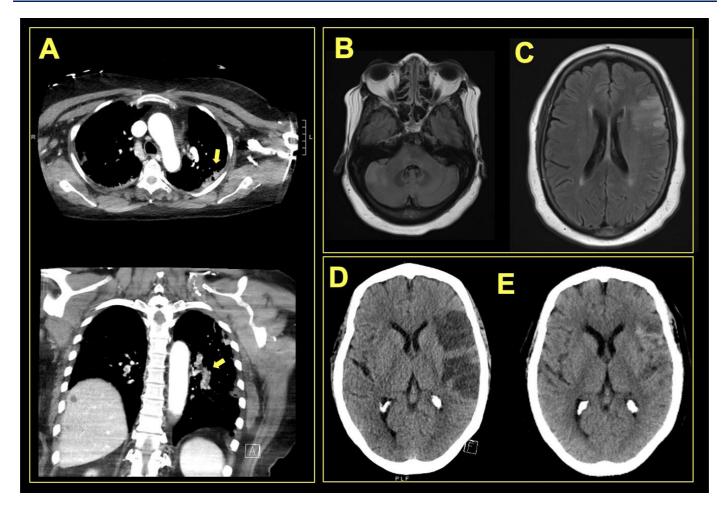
(A-E): Axial and coronal thoracic CT at the time of COVID-19 diagnosis demonstrated pulmonary ground-glass opacities (A). Axial T2 fluid-attenuated inversion recovery (FLAIR) images demonstrated spotty restrictive diffusion in the right pons (B) and right cerebellar hemisphere (C). Left hemisphere stroke is evidenced (D), but likely unrelated to COVID diagnosis. Repeat head CT three weeks later demonstrated progression of left infarct (E).
